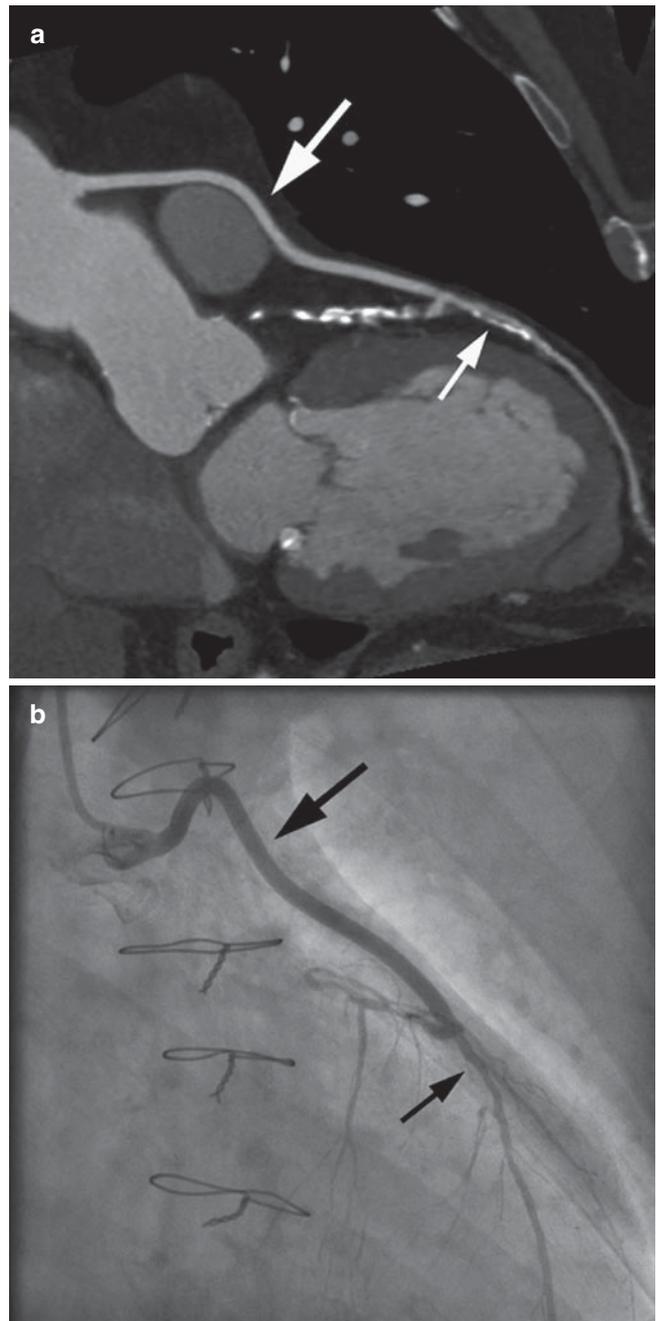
Native coronary arteries in patients after bypass surgery are often severely calcified, which makes their evaluation by CT angiography difficult. (a) Curved multiplanar reconstruction of a bypass graft to the left anterior descending coronary artery (*large arrow*). The bypass lumen is clearly visualized. However, there is substantial calcification of the distal left anterior descending coronary artery. Along with the small vessel lumen, this can cause problems with interpretation (*small arrow*). (b) Invasive coronary angiogram of the same patient, showing the bypass graft to the left anterior descending coronary artery and the distal vessel. No stenosis is present
